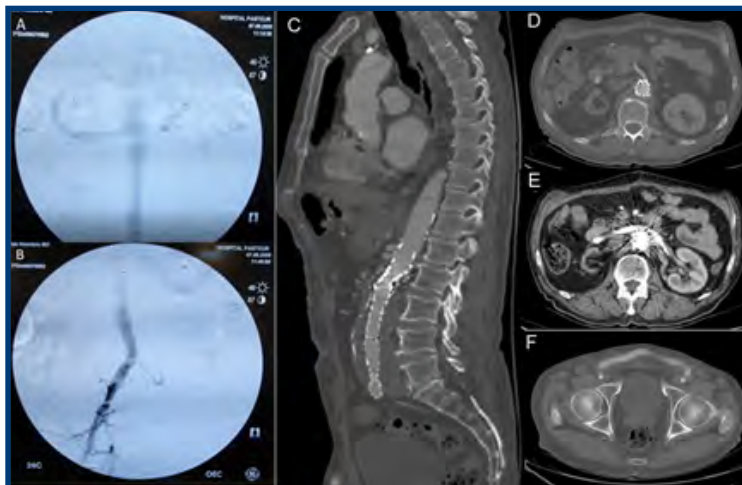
Patent hepatorenal bypass. 2-B. Lack of endoleaks and patency of devices implanted. 2-C. 7-day follow-up coronary computed tomography angiography (sagittal projection): correct device apposition, aneurysmatic sac thrombosis, patency of modules, lack of endoleaks. 2-D. Proximal neck anchoring at the beginning of the patent superior mesenteric artery. 2-E. Patent hepatorenal bypass, metal artifact due to endovascular devices. 2-F. PTFE graft implanted through femorofemoral crossing bypass surgery.
